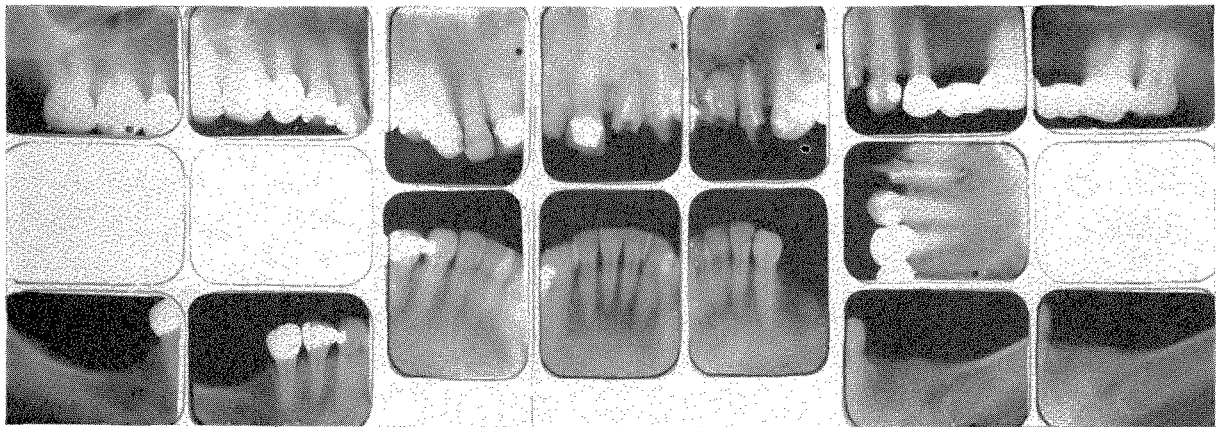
Roentgenograms taken in 1956 reveal strong oral structures in spite of gross negligence in taking care of her mouth.
